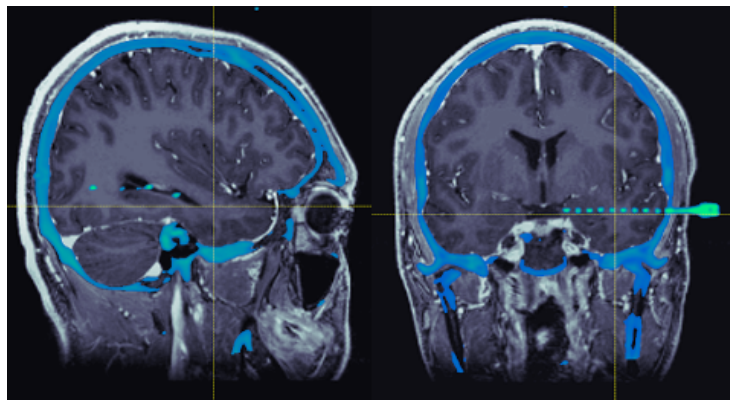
Starred channel RA 4-3 electrodes localization in MRI image
